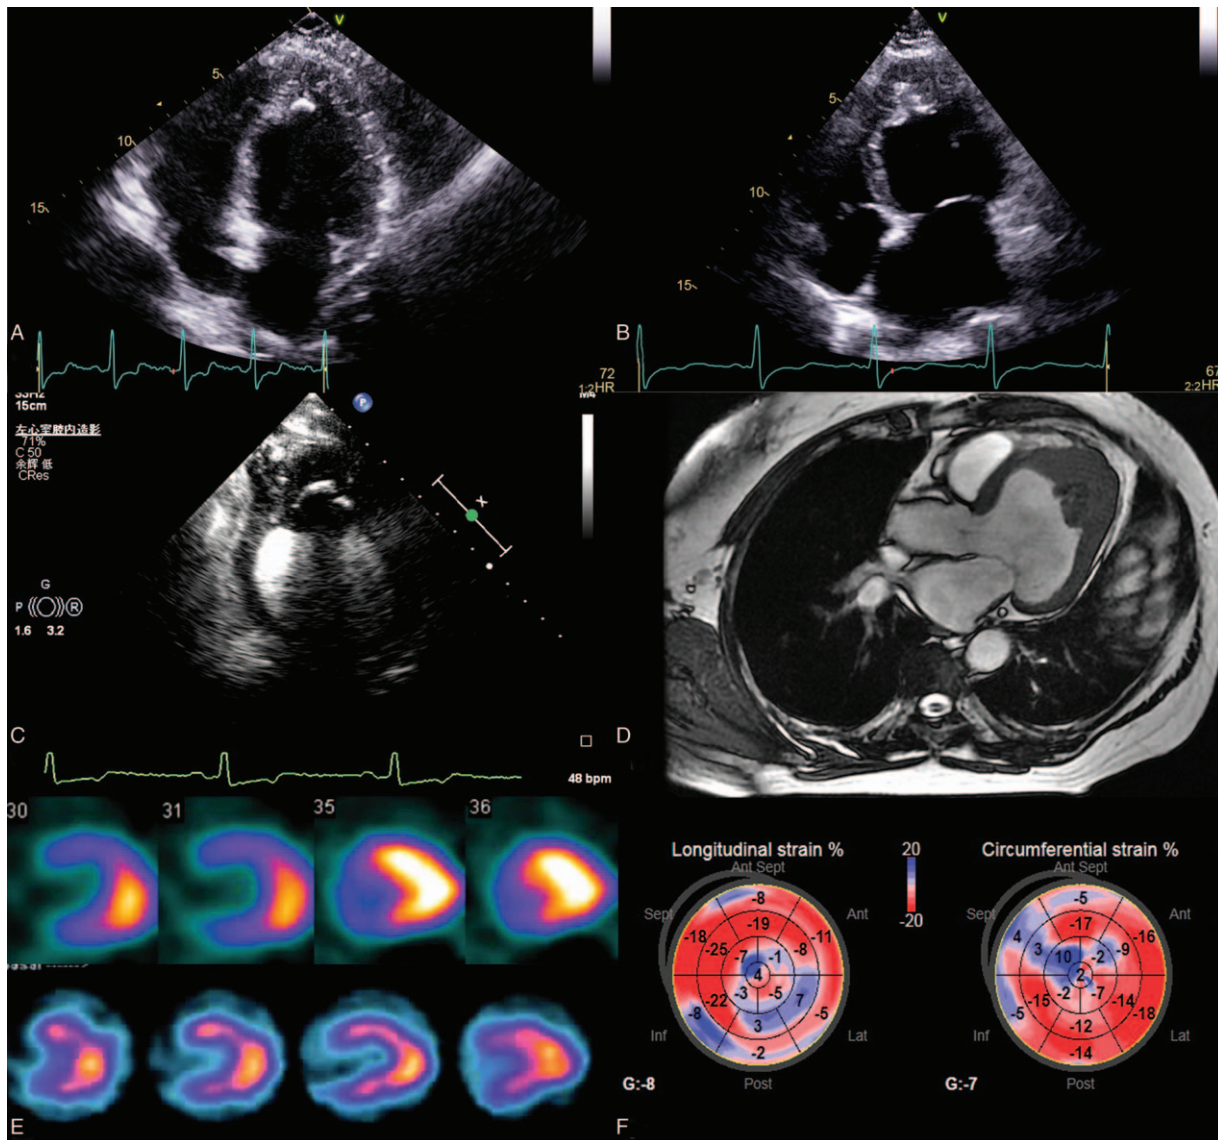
Morphology: the echocardiography of the 2 patients (A and B) showed apical myocardial hypertrophy, endomyocardial fibrosis and calcification, and left ventricular enlargement. LVO (C) revealed a thick ridge of tissue surrounding the calcium, and the echo shadowing behind the calcium and thick endocardium. Magnetic resonance (D) showed significant hypertrophy of the myocardial apex. SPECT (E) revealed increased resting apical tracer uptake and a spade-like configuration of the left ventricular chamber that was observed in the vertical and horizontal axes. The left ventricular strain was significantly reduced (F). LVO=left ventricular opacification, SPECT=single-photon emission computed tomography.
